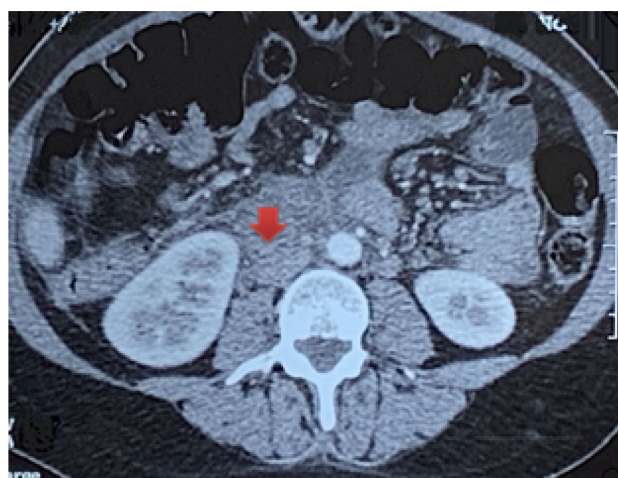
Axial image of abdominal CT scan showing ovarian vein thrombosis (OVT)
